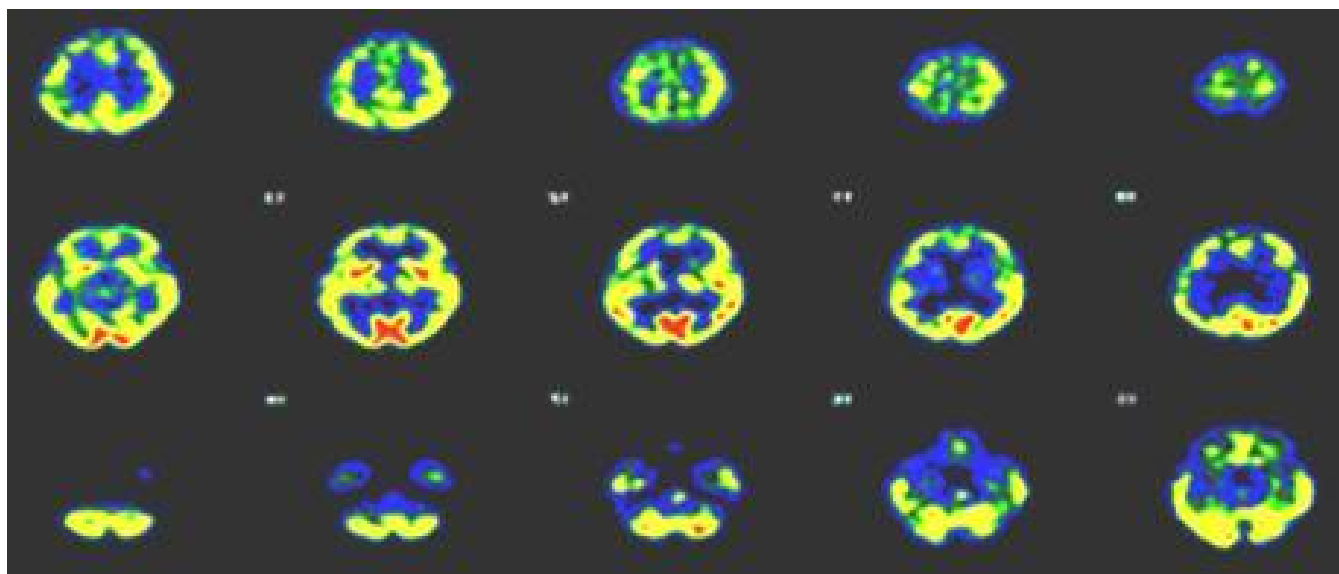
Reduced perfusion of the left thalamus in a 99m-Tc-Bicisate-SPECT
